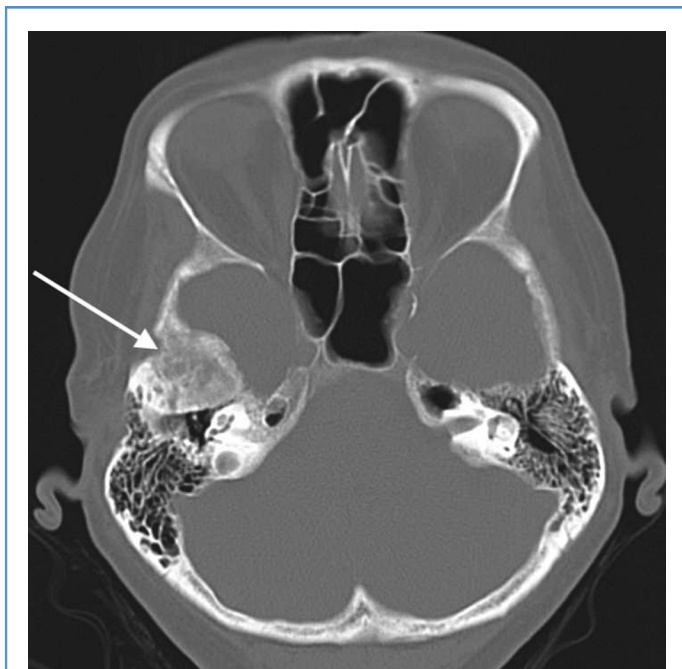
Four years after the last of 3 treatments, noncontrast computed tomography (CT) view showing complete osseous fill-in of the lytic lesion (white arrow).
